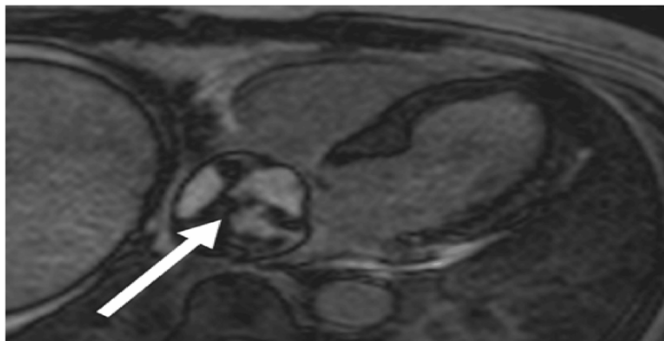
Cardiac MRI showing a large mass in the right atrium (white arrow) demonstrating heterogeneous late gadolinium enhancement in keeping with a tumour.
